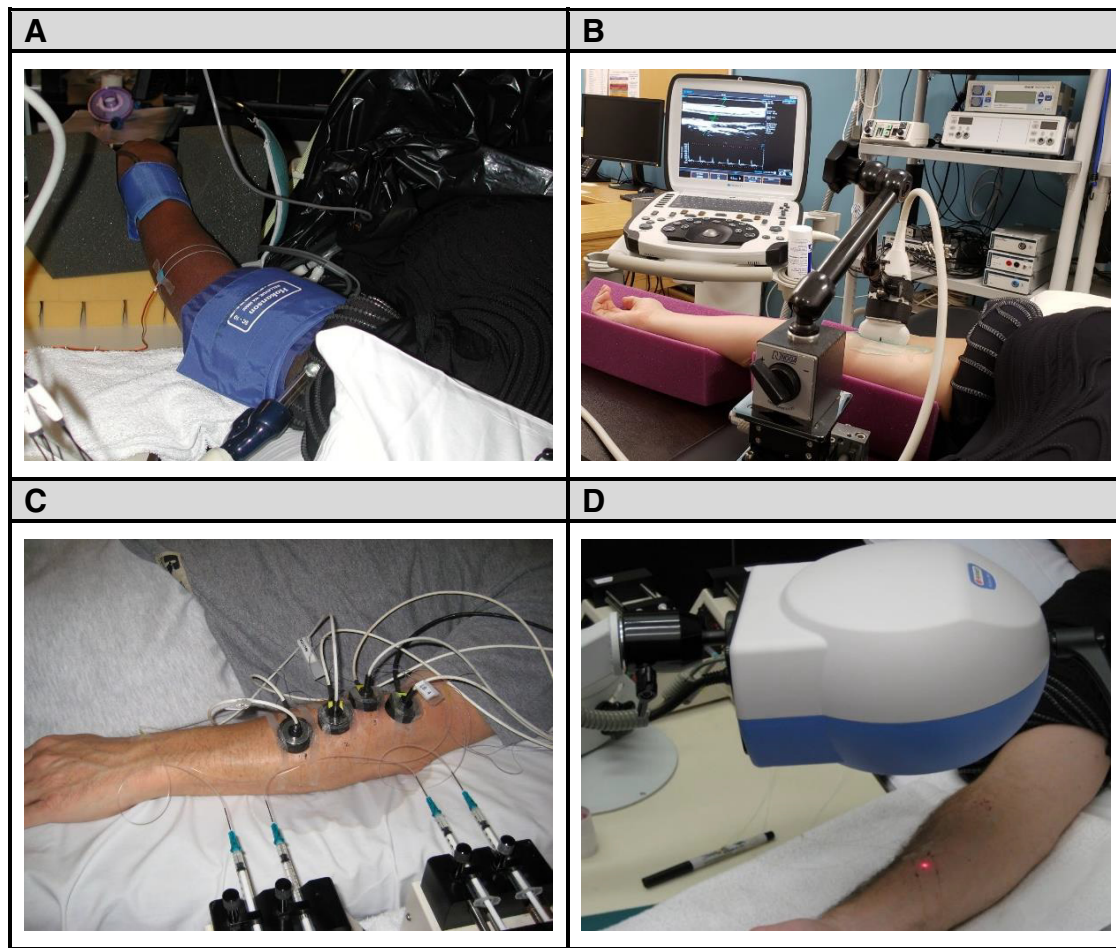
Typical setup of venous occlusion plethysmography (A), Doppler ultrasound (B), laser-Doppler flowmetry (C), and laser-Doppler imaging (D) during passive heat stress protocols.
